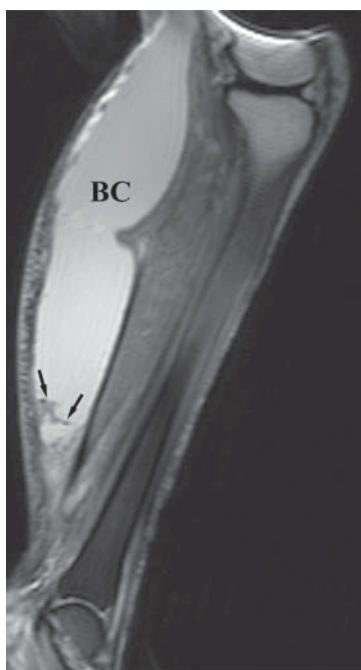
Sagittal fat-suppressed T2-weighted magnetic resonance image clearly showing the extent of the Baker's cyst. Note the internal septations (black arrows) within the cyst. Thickening of the adjacent subcutaneous layer of calf is also evident.
